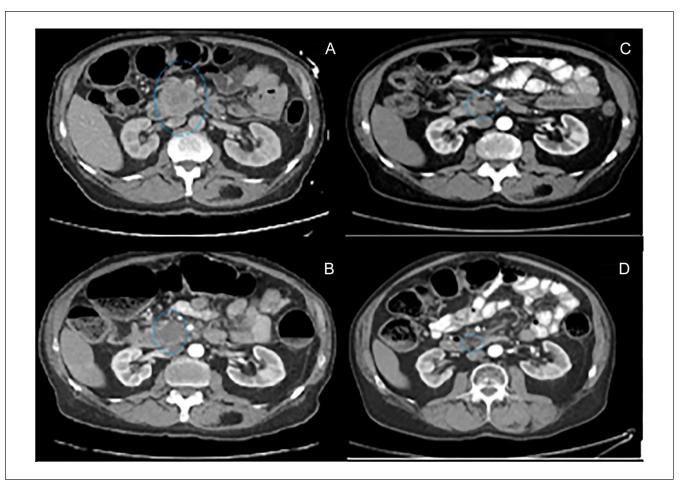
Serial computed tomography of the abdomen and pelvis. (A)  $4.4 \times 4.0$  cm pancreatic head mass at time of diagnosis. (B)  $3.6 \times 2.0$  cm pancreatic head mass at 12 months. (C)  $1.6 \times 1.6$  cm pancreatic head mass at 24 months. (D)  $1.6 \times 1.0$  cm pancreatic head mass at 38 months.
